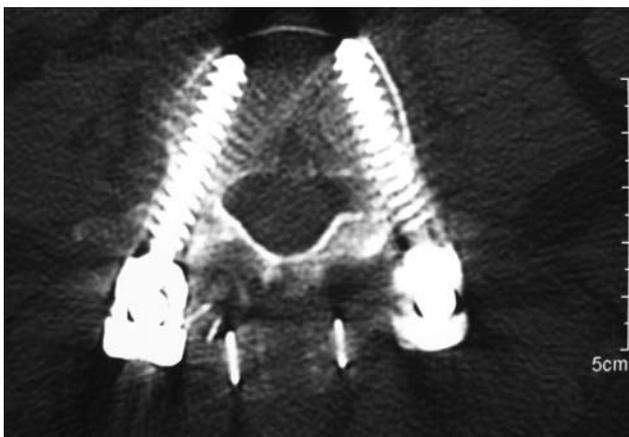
Axial CT view of the patient of Figs. 13 and 14 showing the correct position of the Wallis implant close to the spinous process
